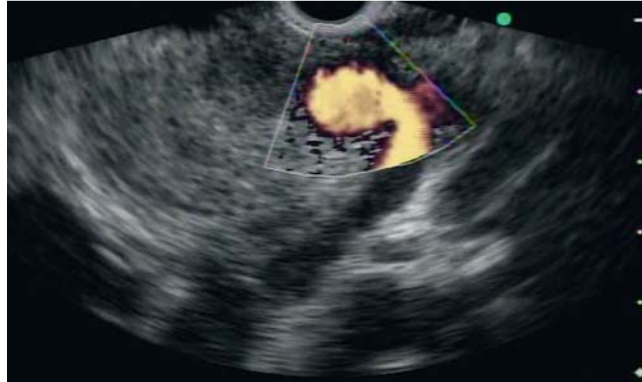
Color Doppler image of the pseudoaneurysm.
